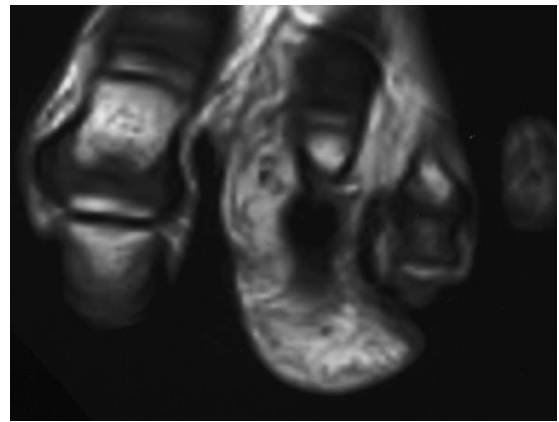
Neural fibrolipoma in an 8-year-old boy. Axial T1-weighted image shows heterogeneous lipomatous mass involving the second toe. Low signal areas correspond to neural tissue, while areas of high signal represent adipose tissue.
